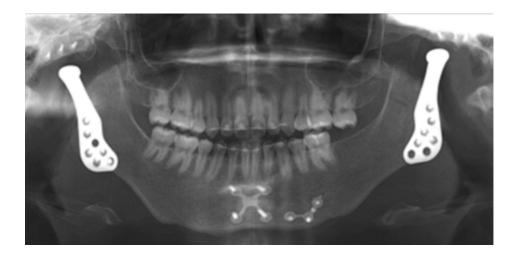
Panoramic radiographs after temporomandibular joint reconstruction with alloplastic implants.
